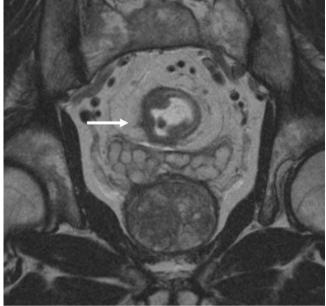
MRI of T3b tumor. Axial T2 image shows a rectal cancer with focal extension beyond the outer muscular layer (T3b) (white arrow). (Courtesy of Vincent Pelsser, MD)
